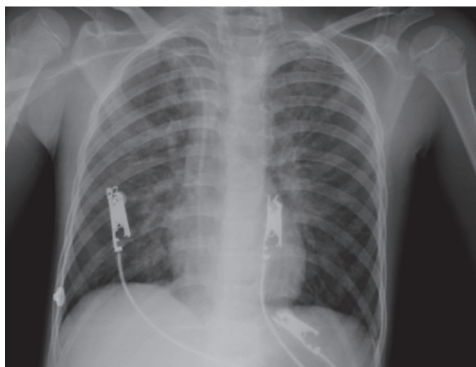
Chest X-Ray soon after plasmapheresis during respiratory distress
